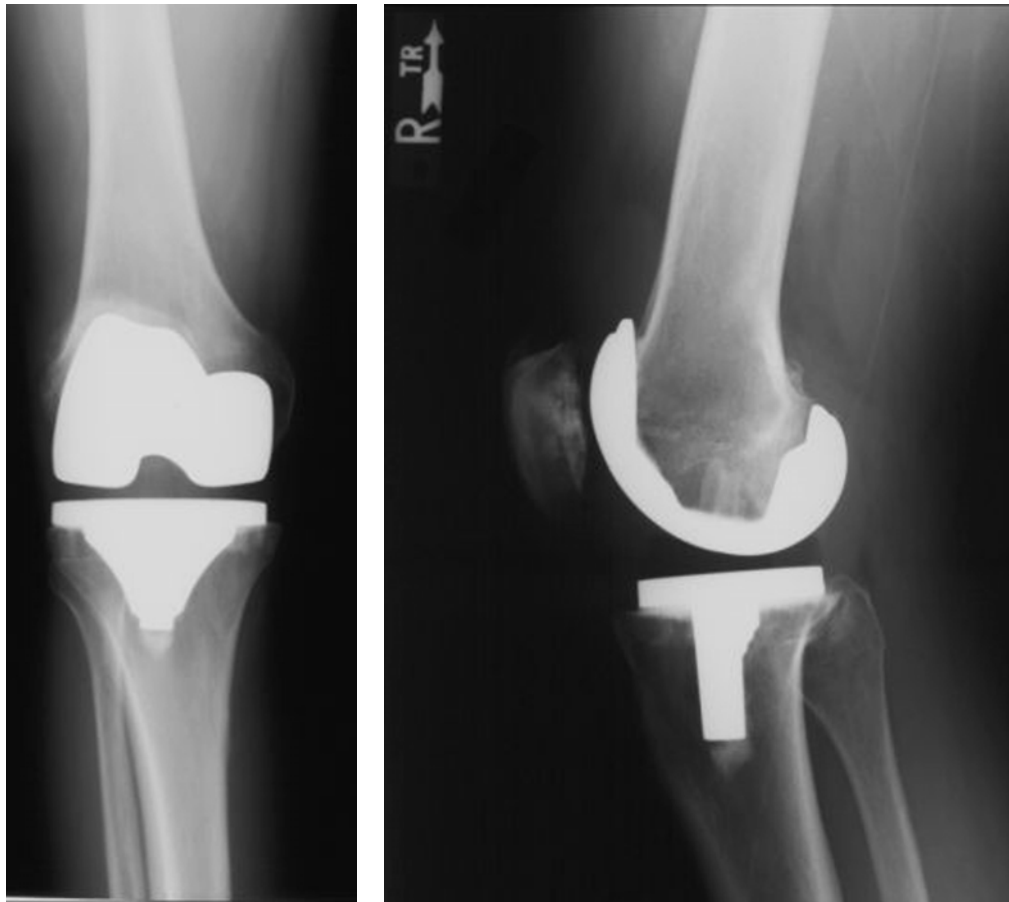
Anteroposterior (A) and lateral (B) radiographs of the knee of a 52 year old woman who received a posterior-stabilized prosthesis.
